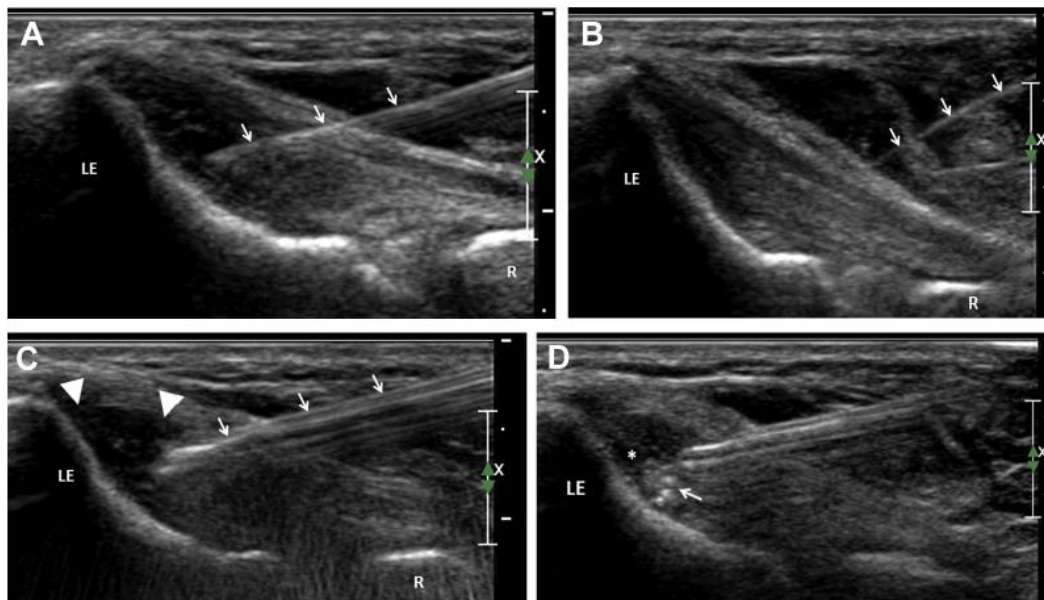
Ultrasound-guided tenotomy of the common extensor tendon. (A) Local anesthesia is delivered with a 27- or 25-gauge needle (→) into the subcutaneous tissues and down to the region of tendinosis. (B) A No. 11 scalpel blade (→) is used to make a 5-mm incision down to the tendon to allow introduction of the cutting device. (C) The TX 2 device (→) débrides the region of hypoechoic degenerative tissue (▶). (D) Once débridement is complete, the hypoechoic degenerative tissue is replaced with anechoic irrigation fluid (*) and hyperechoic microbubbles (→). LE, lateral epicondyle; R, radius.
